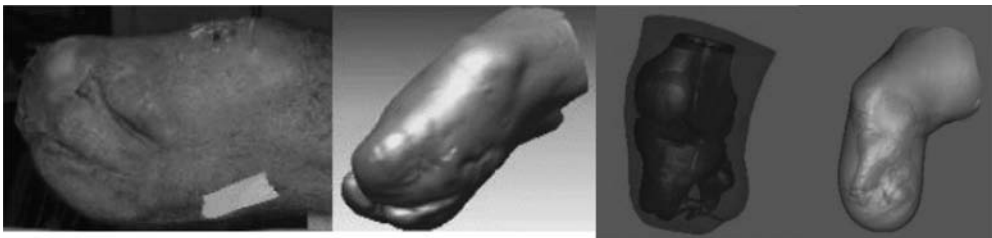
From left to right: stump image (note the signaled landmarks on the top), 3-D laser scanning model, CT skin-bone model, integrated laser/bone model (right). (see colour plate page 517)
